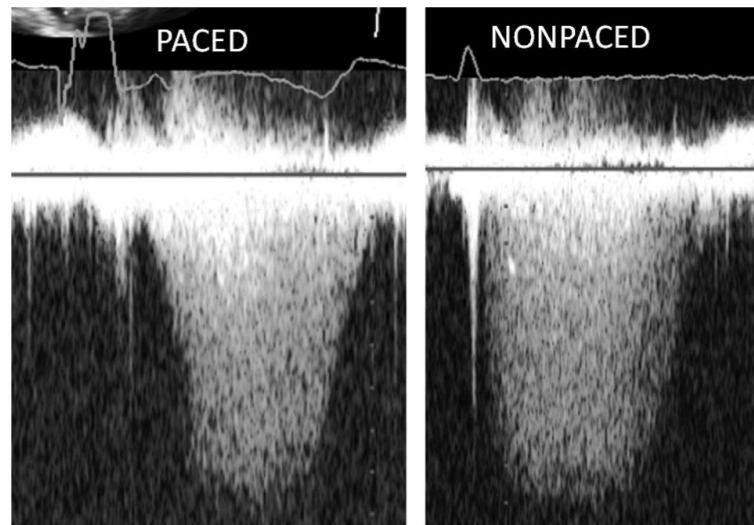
Continuous-wave Doppler regurgitant jet in paced (left) and nonpaced (right) patients. Estimated closing pressure ratio increases from 0.638 (paced) to 0.899 (nonpaced).
